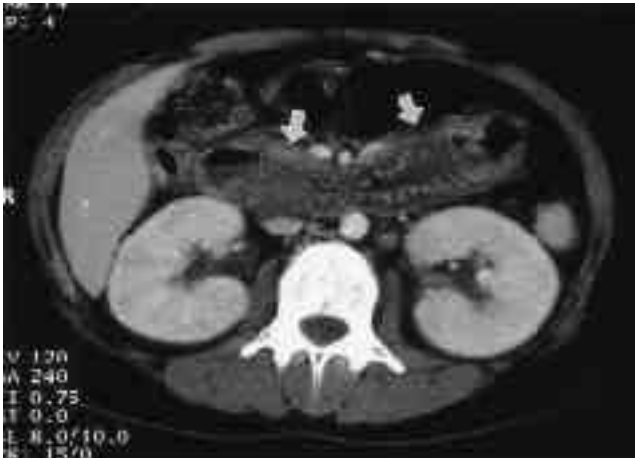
Enhanced abdominal CT scan shows dilated duodenal loops with wall thickening and fluid retention as well as ring-like wall enhancement or target sign (arrows).
